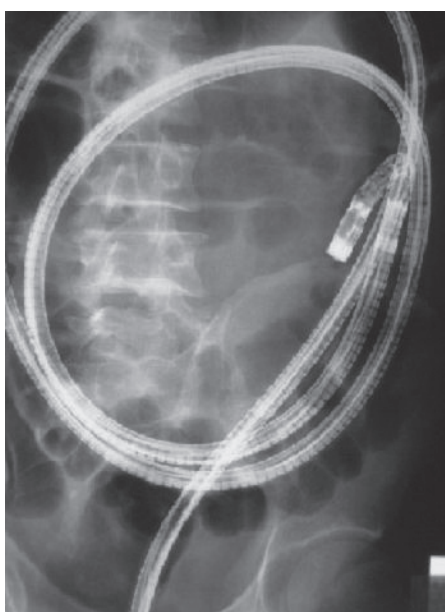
Double balloon endoscopy: X-ray of the abdomen in a patient undergoing ab ano DBE.
